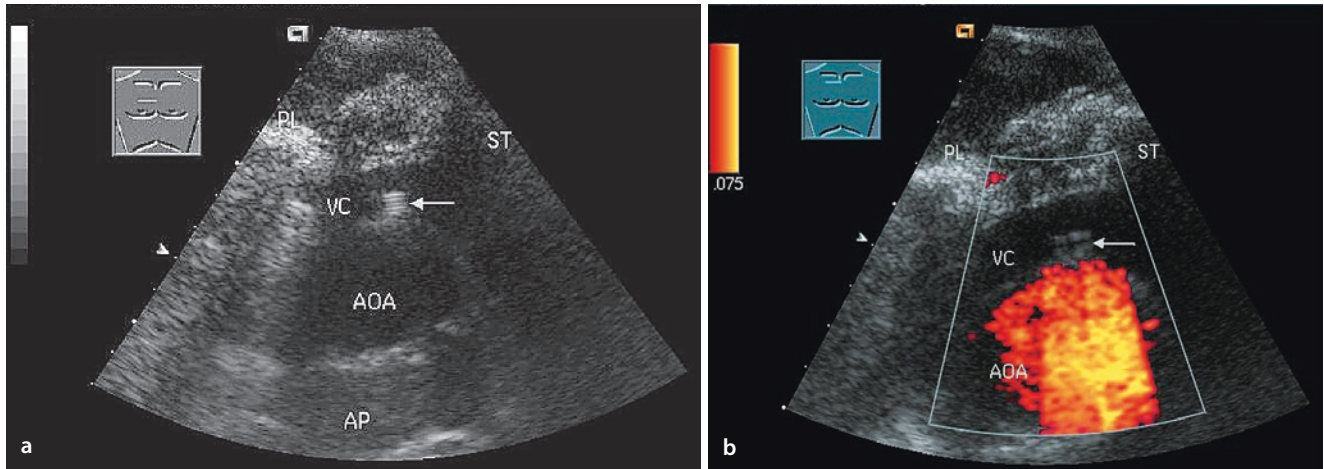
Known non-Hodgkin's lymphoma. a Acute upper inflow congestion. Condition after port implantation. B-image sonography of still parasternal tumor masses. The port catheter can be differentiated
